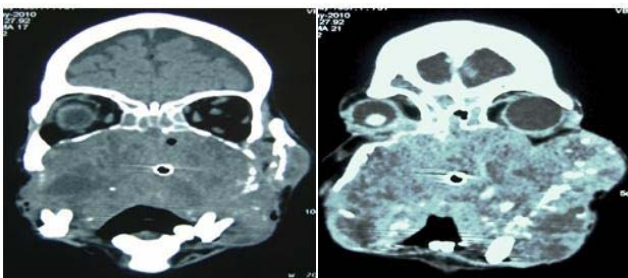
Coronal view computed tomography scan.
